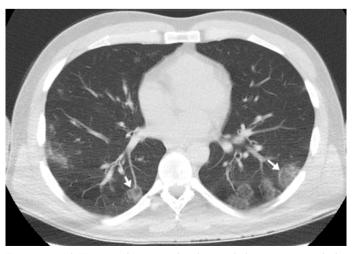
Axial CT image shows peripheral ground-glass opacities with the reverse-halo sign (white arrow). Typical appearance for SARS-COV-2.
